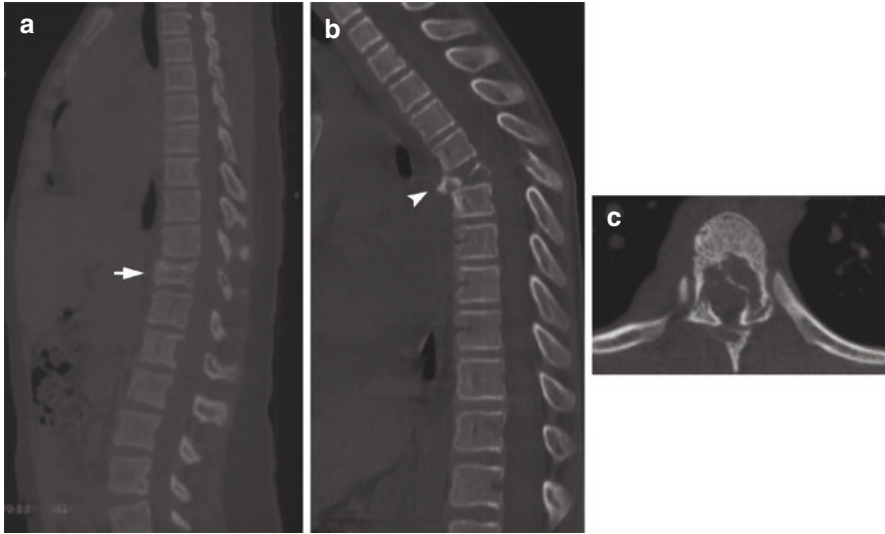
Plain CT scans of the spine suggest vertebral bone abnormalities in three cases of pediatric Cobb's syndrome. (a) Vertebral compression fracture (arrow). (b) Severe pathological bone fracture of the vertebral body and spinal deformity (arrowhead). (c) Extensive destruction of the vertebral body, pedicles, lamina, and spinous process
